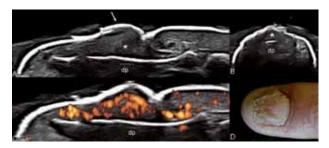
Power doppler sonography revealing marked signal indicative of an increase of blood flow at the nail bed level. (Coll X. Wortsman, Chile).
